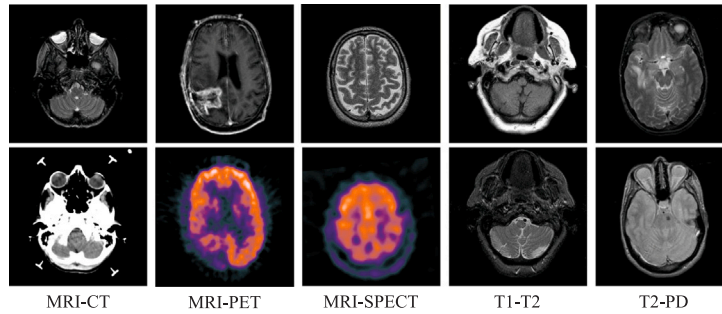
Five kinds of fusion images pairs used in our experiments. From left to right in the picture are: MRI-CT, MRI-PET, MRI-SPECT and T1-T2, T2-PD, where the PET and SPECT are color images. It can be intuitively seen from the figure that different types of images show completely different visual effects with different image characteristics and information.
